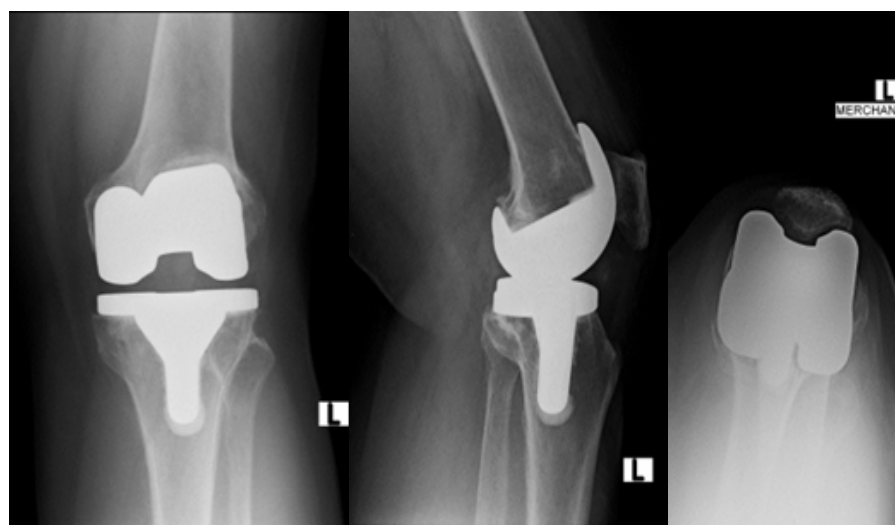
Knee Radiographs Examination Before the Patellar Resurfacing Procedure.
